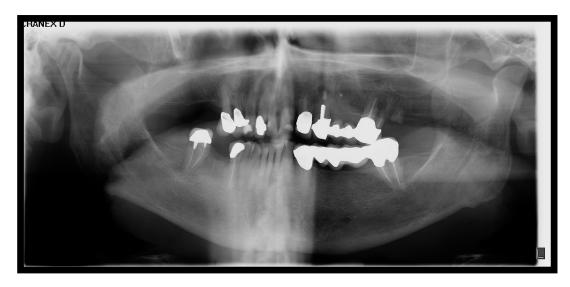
OPG radiograph taken at the TAKO centre
